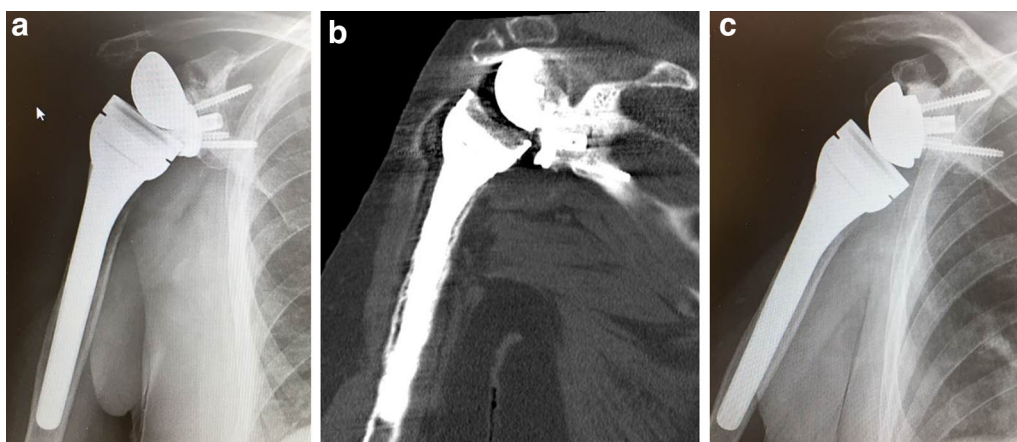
Disassembly of the prosthetic components in RSA. a Disassembly of the glenosphere in RSA. b Pre-operative CT in disassembly of glenosphere without baseplate loosening. c Post-operative X-ray after revision with glenosphere replacement
